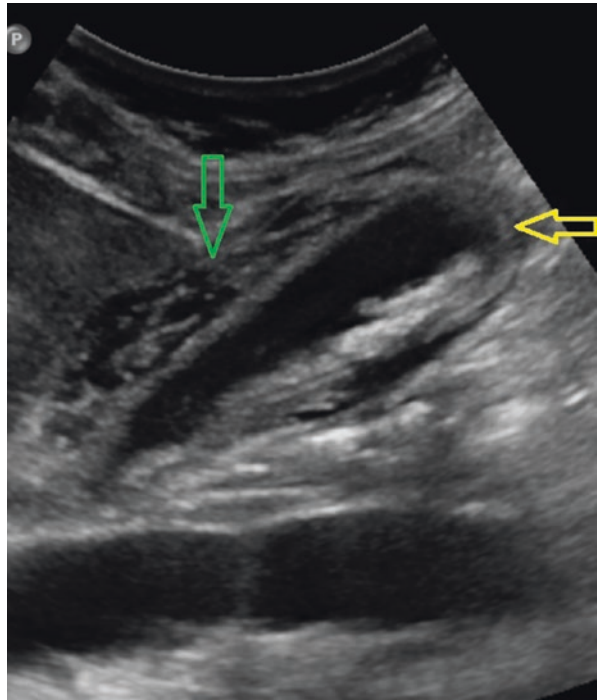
A 50-year-old lady presenting with 4-day history of constant biliary pain. An ultrasound demonstrated a thickened oedematous gallbladder wall (red arrow) with pericystic fluid (green arrow) and a large amount of sludge (yellow arrow) within the gallbladder lumen. No stones could be demonstrated in the gallbladder. At urgent LC she had gangrenous cholecystitis with a 4 mm stone impacted in the cystic duct
